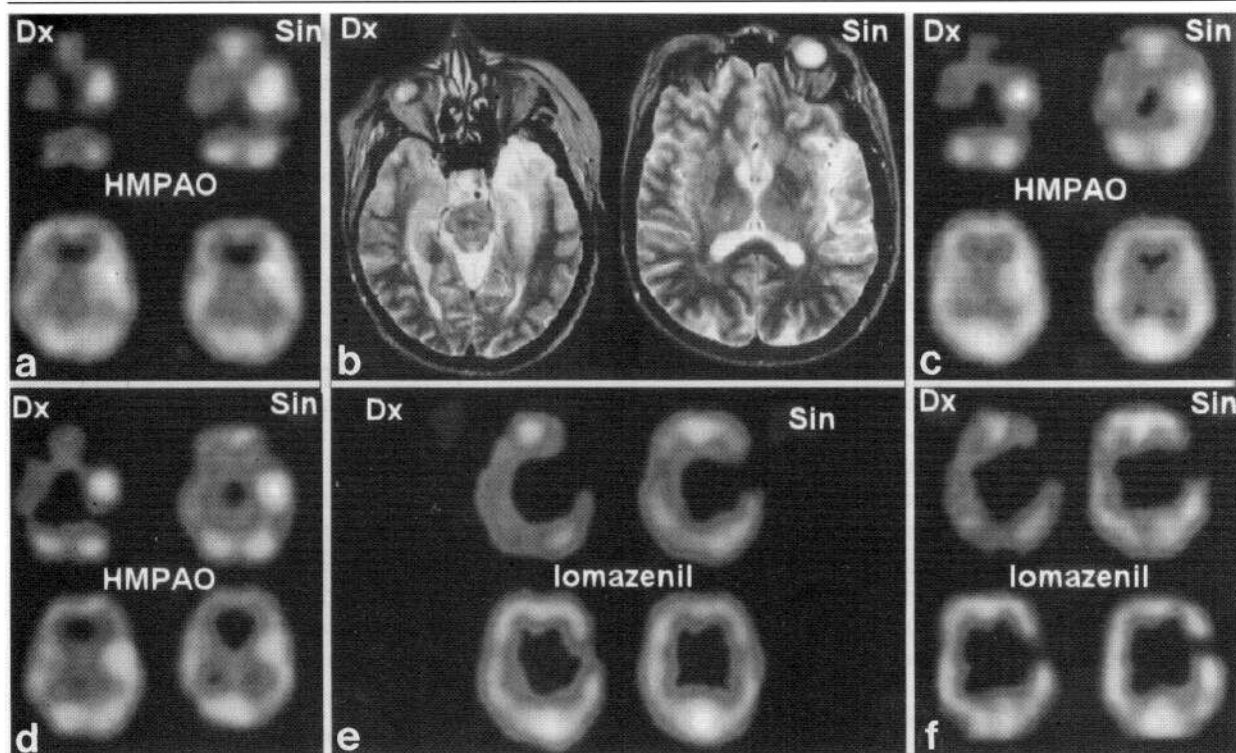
Patient 2. (A) Hyperfixation of ^{99m}Tc -HMPAO on the left temporal lobe on day 3 after admission. There is a 26% side-to-side difference in the temporal areas. At this time the patient had periodical lateralized complexes on EEG, but no seizures. (B) 1.0 T T2-weighted MRI demonstrating typical increased signal intensity for HSE on the left anterior temporal lobe extending to insula. (C, D) Follow-up ^{99m}Tc -HMPAO SPECT on days 19 and 40 demonstrating the continuing hyperfixation of ^{99m}Tc -HMPAO in the left temporal lobe. There is a side-to-side difference of 26% and 25%, respectively. Although the hyperfixation remained almost unchangeable, the patient improved markedly and the periodical complexes had vanished. (E, F) ^{123}I iomazenil SPECT scans performed on days 7 and 20 after admission demonstrating worsening neuronal loss on the left temporal lobe. In the first scan there is a 32% and in the second a 44% side-to-side difference in the temporal areas.
